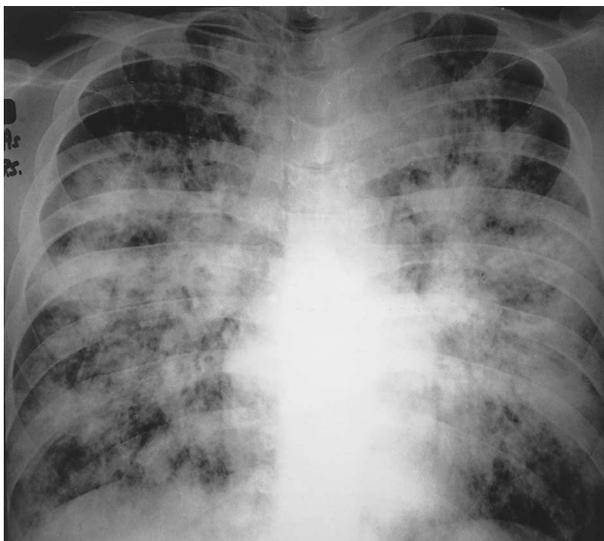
'Cepacia syndrome': chest X-ray of this 23-year-old man with cystic fibrosis shows the typical appearance of 'cepacia syndrome' with fulminant bilateral necrotising pneumonia. He had acquired *Burkholderia cepacia* genomovar III infection 7 years previously during an outbreak of infection amongst patients with cystic fibrosis attending a holiday camp. His lung function showed an accelerated rate of decline in the years after infection and he then developed a severe exacerbation that failed to respond to treatment and progressed to a fatal fulminant pneumonia over a 2-week period.
